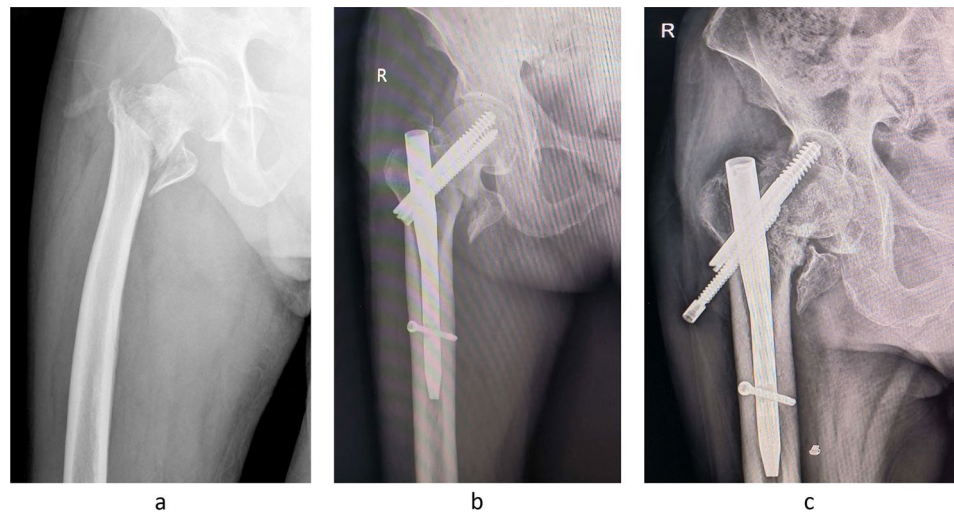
At 31 months postsurgery, a 96-year-old male patient presented at the hospital seeking evaluation for persistent right hip pain. (a) Preoperative X-ray revealed a comminuted fracture involving the right femoral trochanter. (b) First-month postoperative X-ray. (c) Follow-up at the 31st month after surgery; the patient had a cut-through of the length tension screw, and the compression screw was withdrawn
